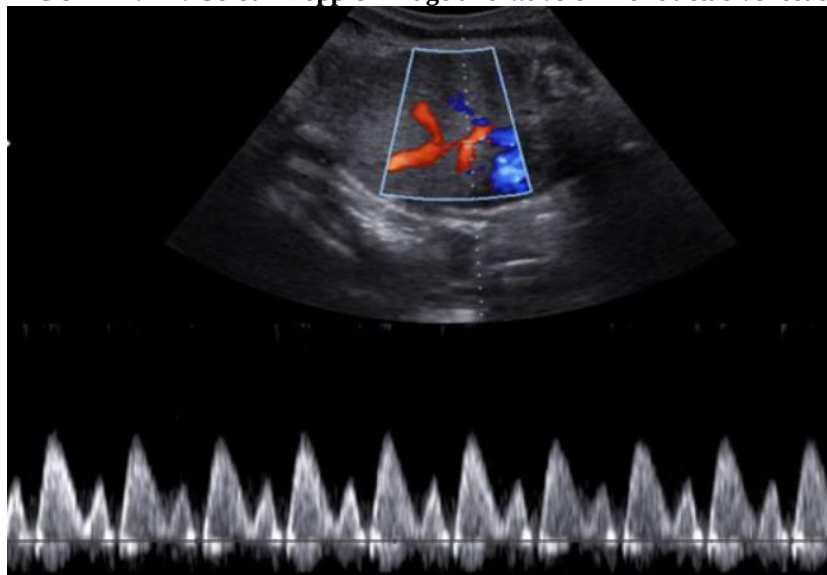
FIGURE IV B :NORMAL DOPPLER WAVEFORM OF DUCTUS VENOSUS.
